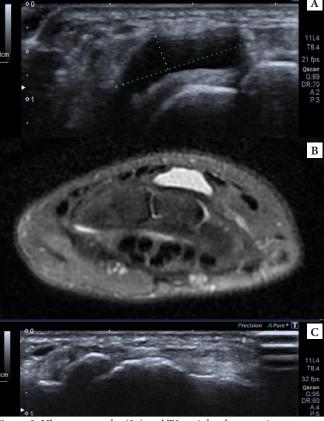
Ultrasonography (3a) and T2-weighted magnetic resonance imaging (3b) of the patient with dorsal wrist ganglion. After the percutaneous treatment, the first-month follow-up ultrasonography (3c) showed that the cyst had completely disappeared.
